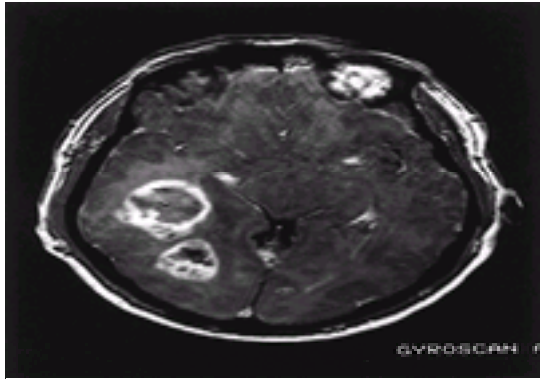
Glioblastoma multiforme. Axial T₁-weighted gadolinium-enhanced MRI showing a right temporo-occipital lesion with irregular rim enhancement, central hypointensity suggestive of necrosis, and edema extending anteriorly into the temporal lobe. The two apparent components of this tumor on this image merged lower in the temporal lobe.
